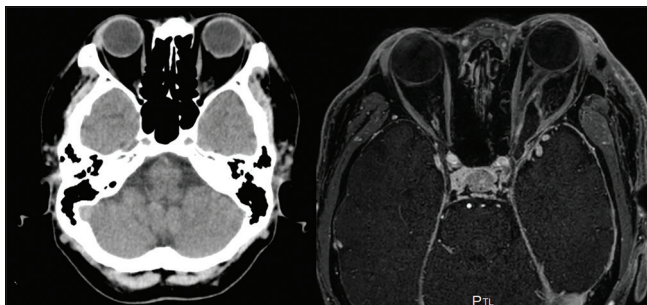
Postoperative imaging. Computed tomography showed the proptosis disappeared (left). Gadolinium-enhanced fat suppression T1-weighted magnetic resonance imaging showed subtotally resected tumor and well-visualized optic nerve. Note the optic nerve compression was relieved (right).
